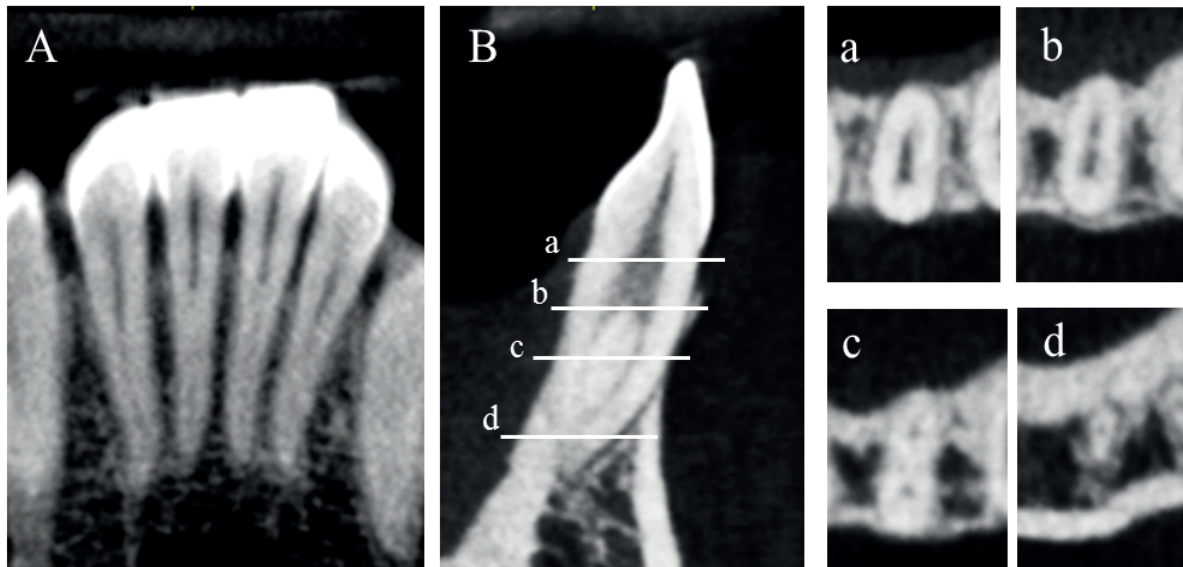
A CBCT image of a mandibular incisor with type III Vertucci root canal configuration. Image A shows a coronal section view of mandibular incisors, image B shows sagittal section view of mandibular central incisor. Different axial section views are shown on images a, b, c, d. Notice how in coronary part of the root, a root canal starts as a single (a), then separates into two canals (b, c) and finishes as one root canal at the apex (d).
